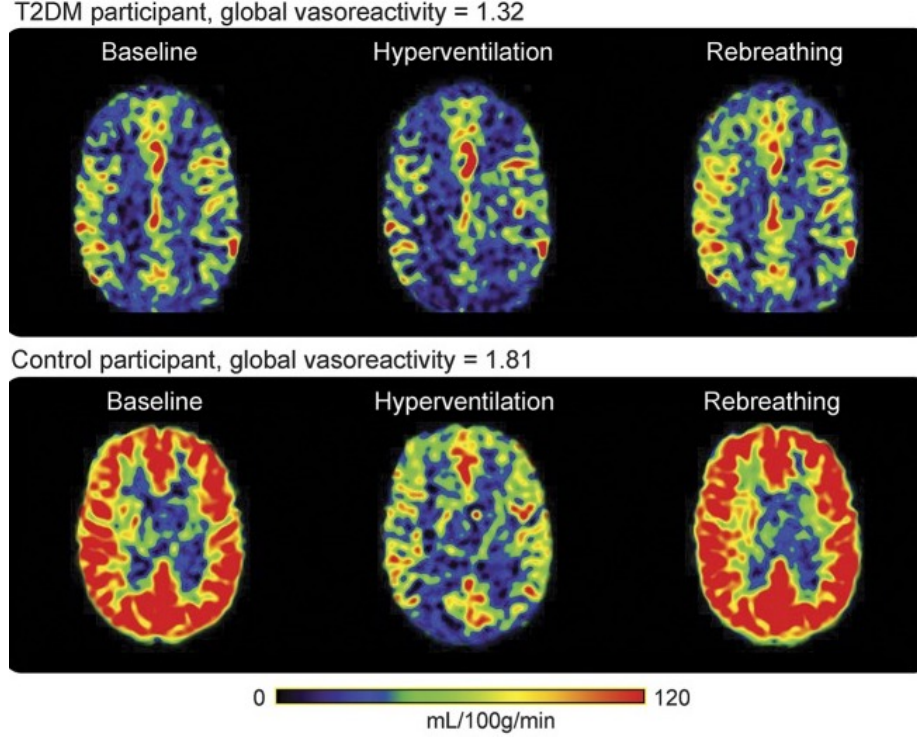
Differences in global vasoreactivities arise in the MRI scans between the brain of a T2DM participant and the brain of a control participant as the participants exhibit different breathing patterns, each pattern involving a different amount of carbon dioxide [6]. The T2DM participant has a much lower overall global vasoreactivity.
